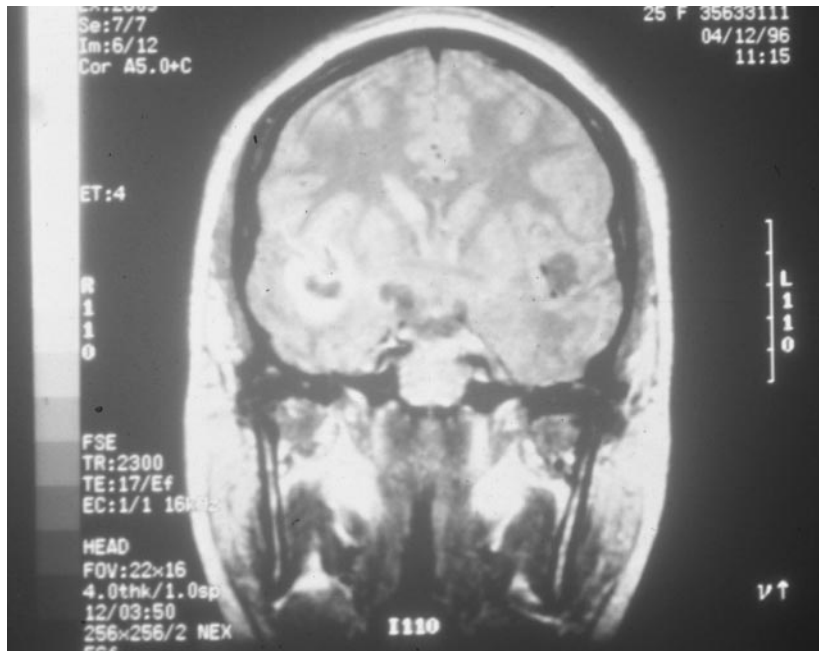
Neuroimaging studies from patients with neurocysticercosis. (*left, top*) CT scan revealing multiple calcifications of inactive parenchymal disease. (Reprinted from Reference 5 with permission.) (*left, bottom*) MRI with gadolinium contrast of a parenchymal cyst in the colloid stage. The hypodense cyst fluid is surrounded by the cyst wall, which enhanced with contrast. (*above*) MRI with gadolinium contrast revealing inflamed giant cysticerci in the Sylvian fissures. A lacunar infarction is visible as an enhancing lesion in the right basal ganglion. The basilar cisterns are also packed with thin-walled cysticerci.
